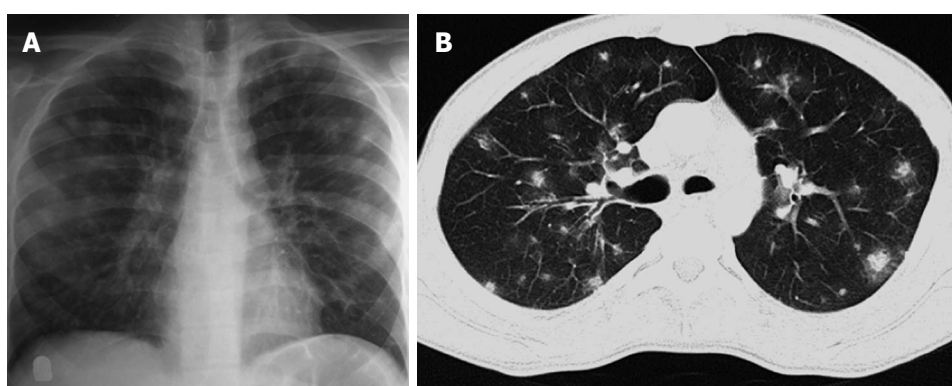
A 17-year-old boy with acute lymphocytic leukemia along with angioinvasive aspergillosis. Chest radiograph (A) showing multiple fluffy nodules in bilateral lung fields. High resolution CT image (B) of the same patient shows multiple nodules with surrounding ground glass opacity (halo sign).
